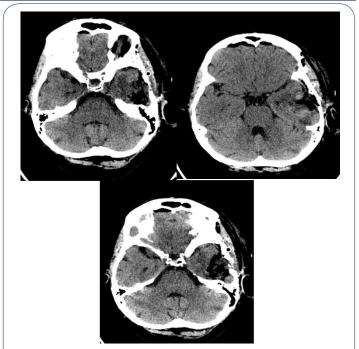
Post operative head CT.
